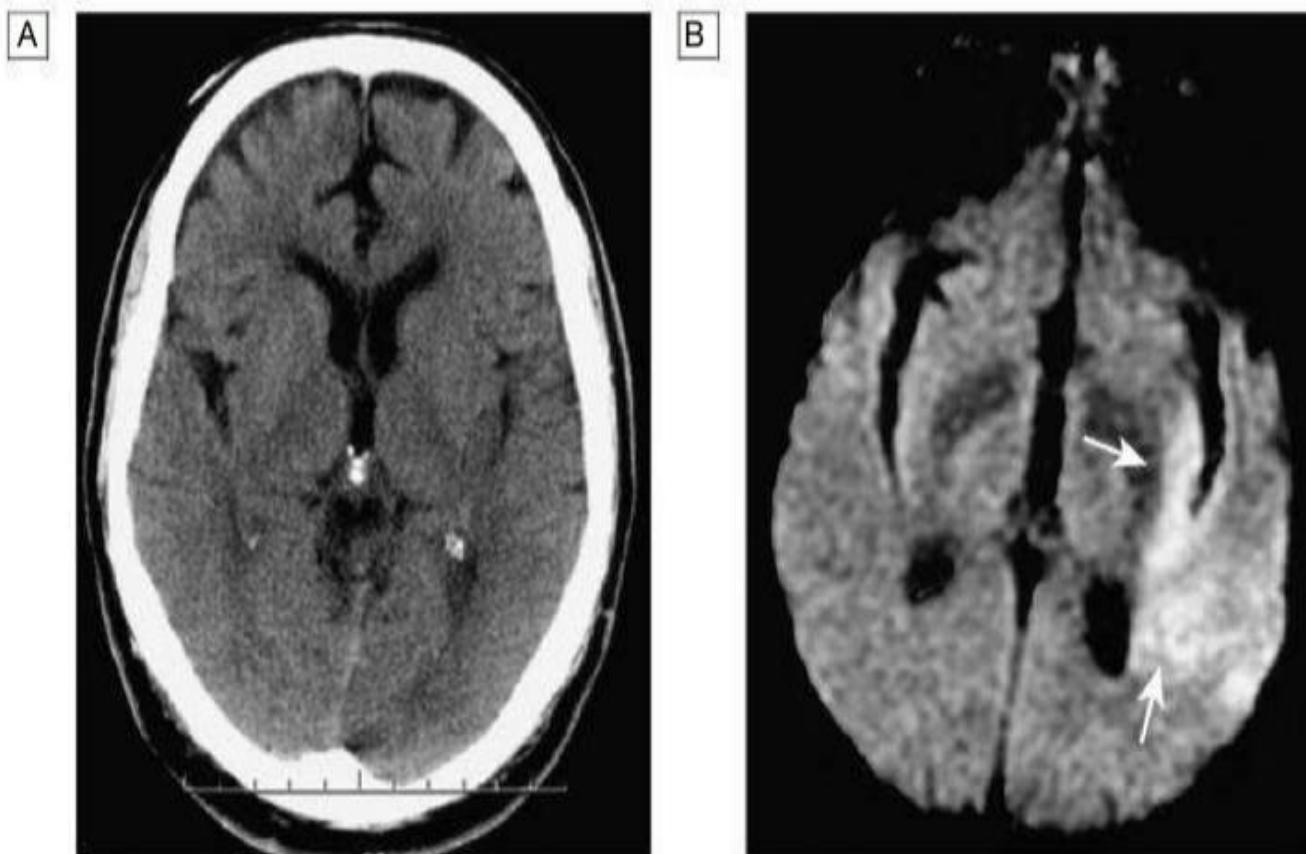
Acute stroke seen on computed tomography (CT) scan with corresponding magnetic resonance imaging (MRI) appearance. A CT may show no evidence of early infarction. B A corresponding image seen on MRI diffusion weighted imaging (DWI) with changes of infarction in the middle cerebral artery (MCA) territory (arrows). (A, B) Courtesy of Prof. A. Farrell and Prof. J. Wardlaw.
